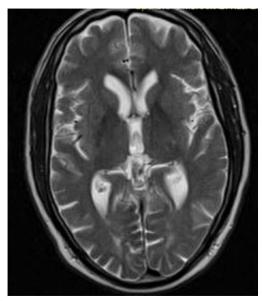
Brain MRI demonstrating ischemic changes in MCA territory
